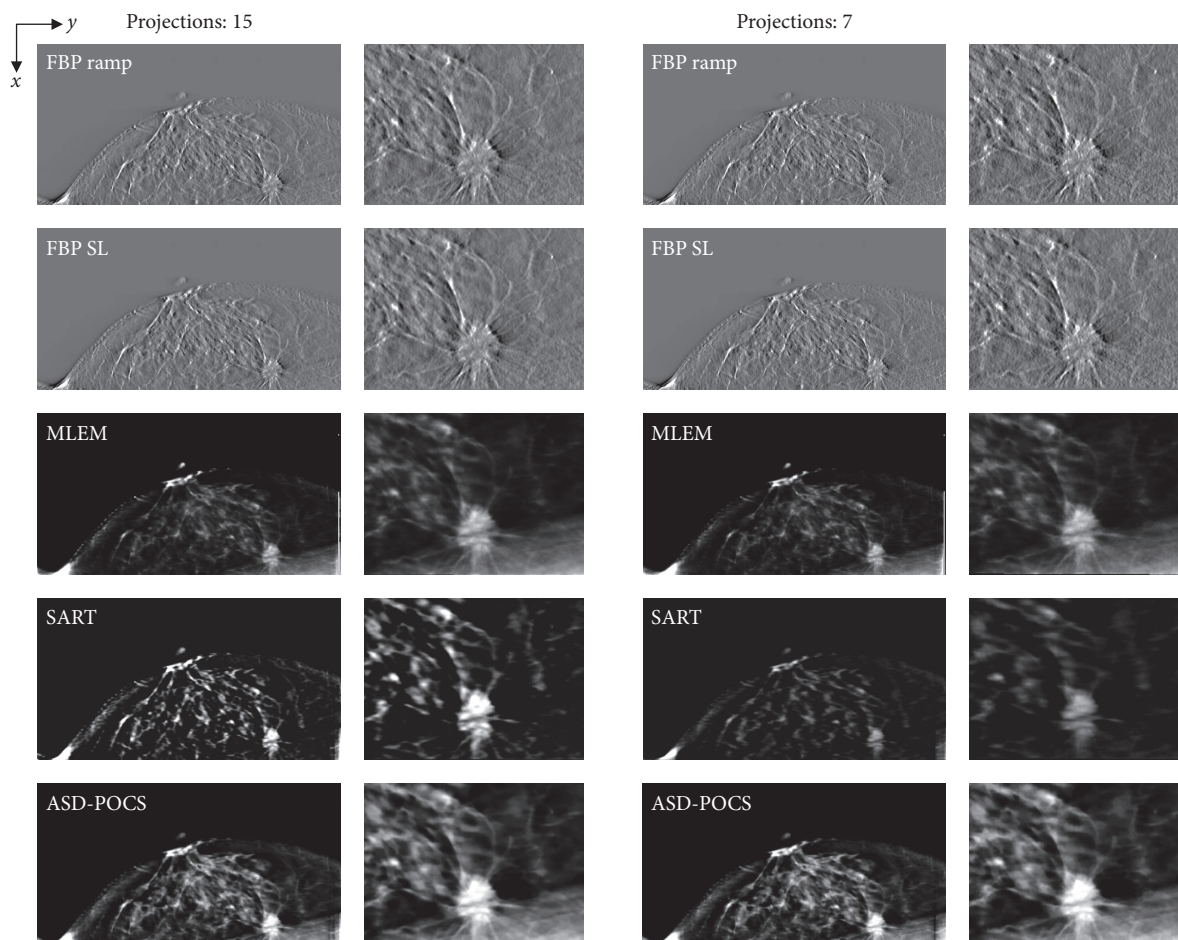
Case 2. Comparisons between images obtained at different projection numbers (normal: 15, half: seven) using each tomosynthesis reconstruction algorithm in the in-focus plane. The X-ray source was moved horizontally along the image. Zoomed images depict the lesion areas. For each corresponding set, IR (MLEM, SART, and ASD-POCS) images are displayed at the same window width and level, whereas the FBP images have a larger window widths because the backgrounds are less flattened and the gray levels in larger areas would be out of scale in narrower windows.
